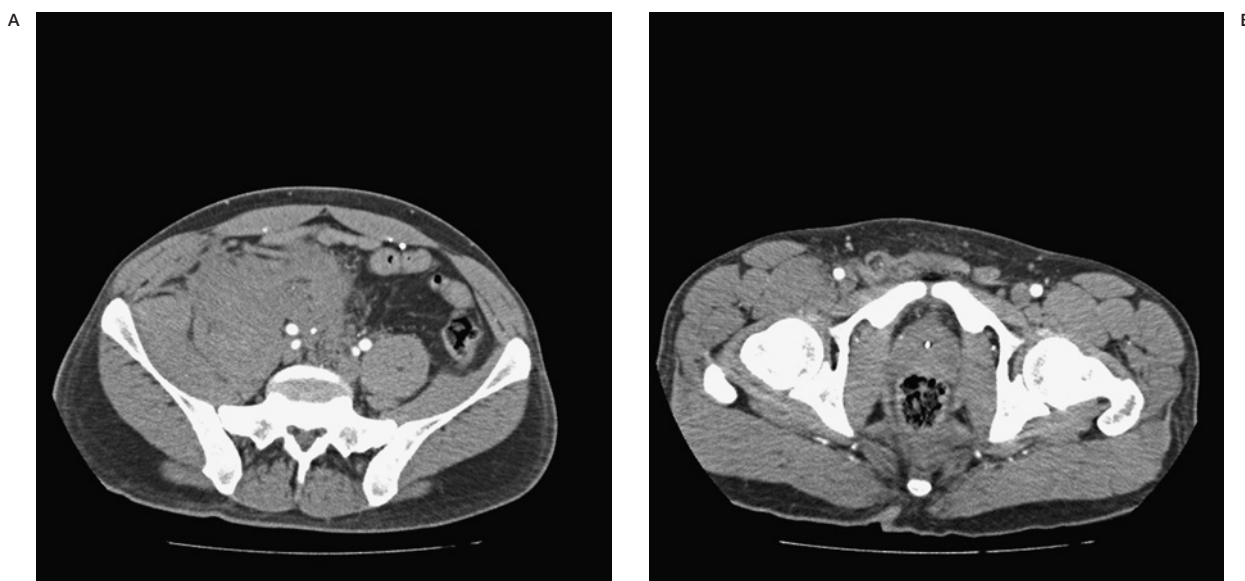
A) CT abdomen revealing a large right-sided retroperitoneal hematoma. B) CT pelvis with right femoral artery without active extravagation of contrast.
